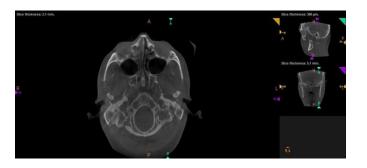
Axial section of CBCT shows an altered shape of the condylar head bilaterally
